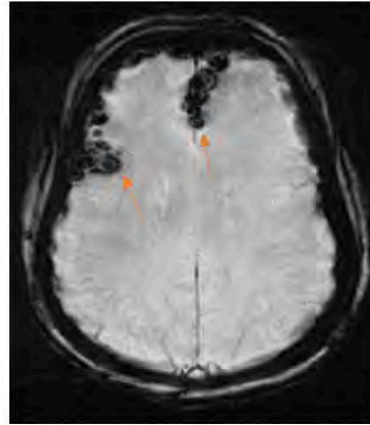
brain MRI showing similar findings of pneumocephalus within the bifrontal subarachnoid space. No evidence of infarct or midline shifts.
